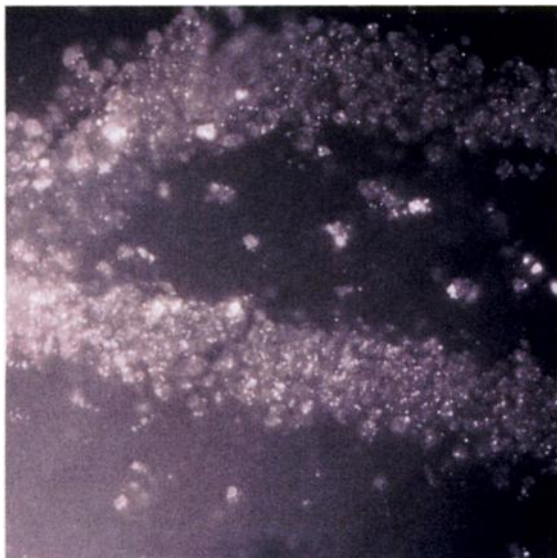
Accumulation of a fluorescent FDG analogue near the nuclei of cells (Mathews W, Baidoo K, and Wagner, HN, Jr., unpublished data).
